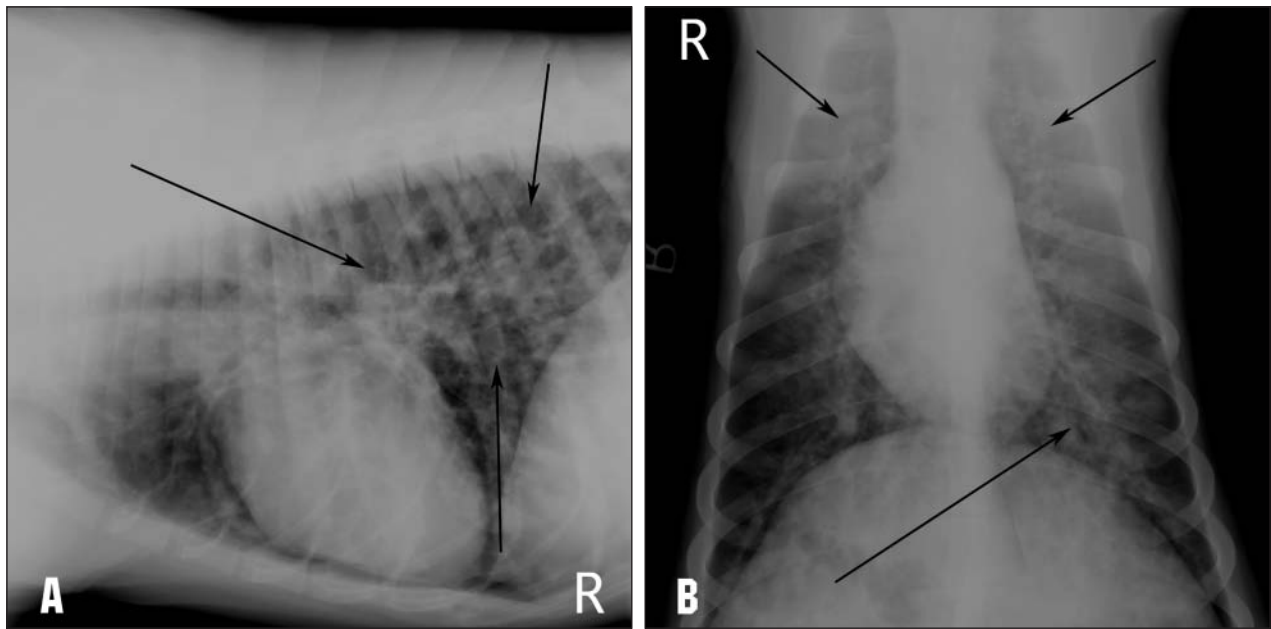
Same radiographic views as in Figure 1. Notice the severe, diffuse bronchointerstitial pattern (arrows).
